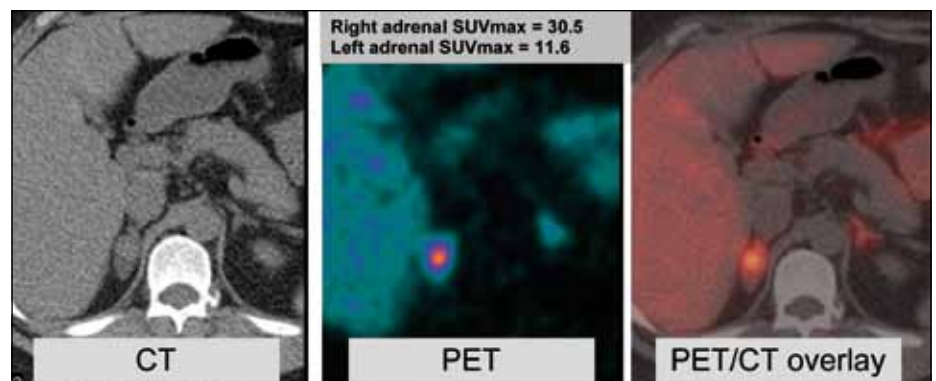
11C-metomidate positron emission tomography-computed tomography (PET-CT) study for case 2. SUVmax = maximum standardized uptake value.
